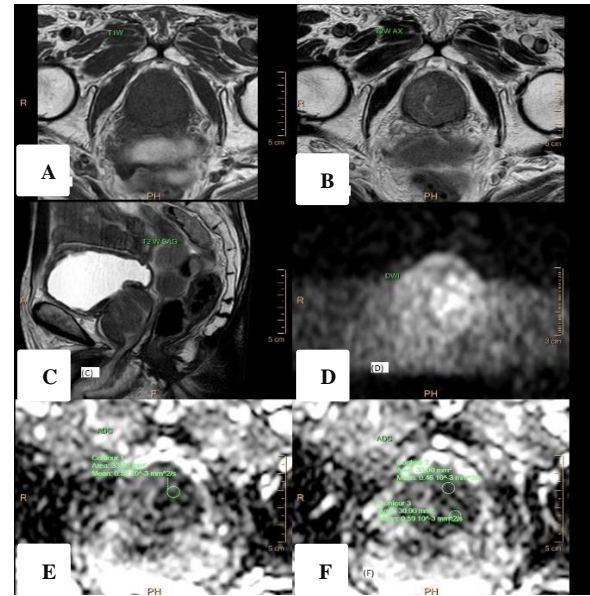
MRI of TZ and PZ adenocarcinoma, (A) Hypo-intense on T1Wi, (B, C) Multifocal hypointensity on T2Wi in peripheral zone as well as transitional zone, (D) On DWi, showing diffusion restriction, (E, F) Low ADC values.
